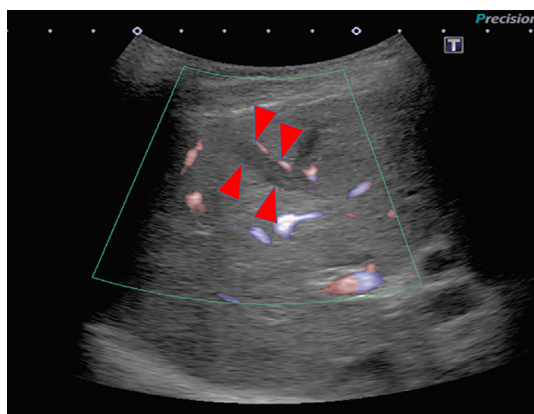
Color Doppler ultrasonographic image showing a solid tumor in the portal vein (red arrowhead).
